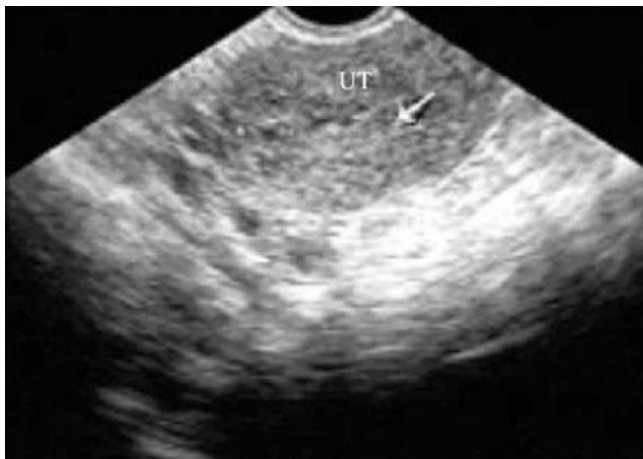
Intrauterine inflammation. A 25-year-old patient, with the complaint of abdominal pain, fever for 1 week after abortion. Sonogram shows inhomogeneous echo in the uterine cavity
